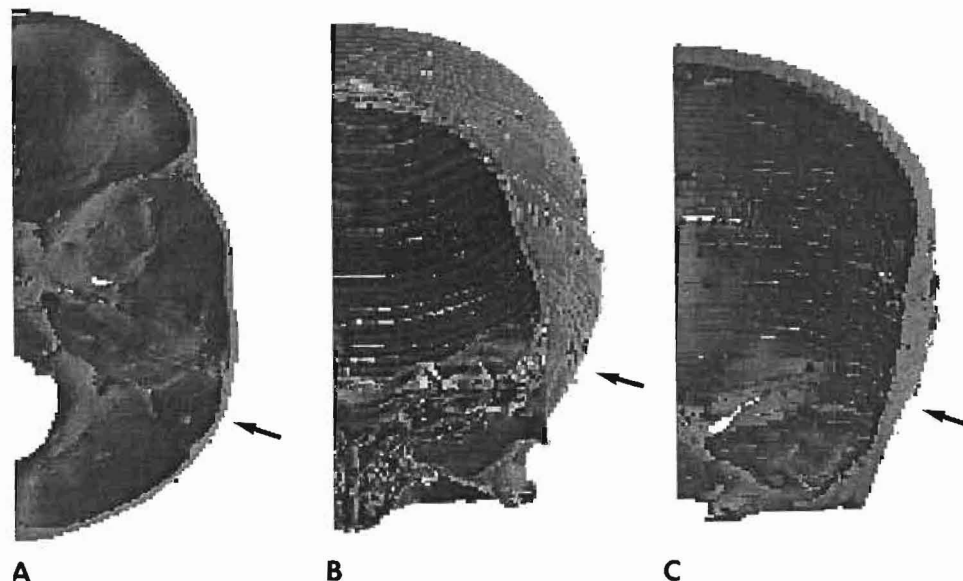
Three-dimensional reconstruction of radiographs of 12-month-old child's skull. A) Horizontal section parallel to orbitomeatal plane. B) Coronal-horizonal section at 45° to Frankfurt plane. C) Coronal section at right angles to Frankfurt plane. Curvature of bone where implant will lie in three sections is marked with arrow.
